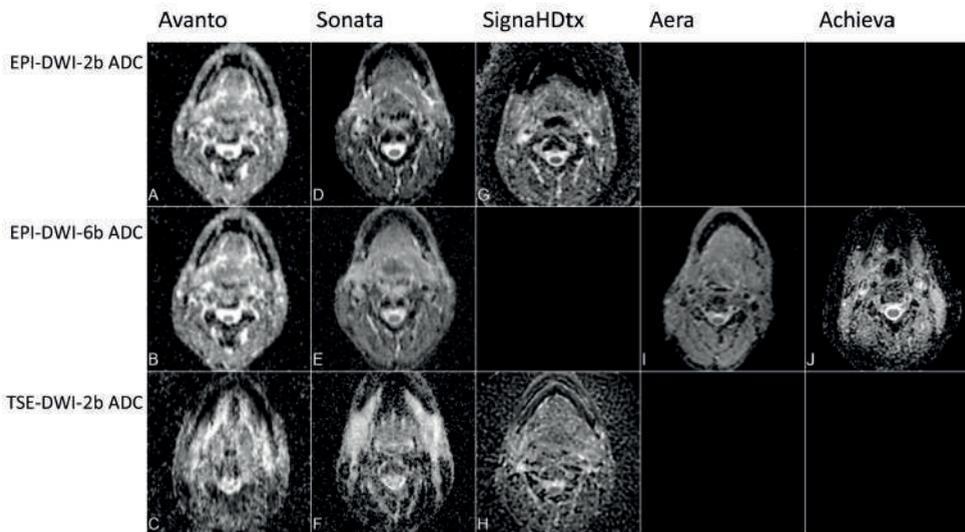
ADC maps of all DWI sequences on all MRI systems. On Signa HDtx EPI-DWI-6b was not performed. On Aera and Achieva EPI-DWI-2b ADC was extracted from EPI-DWI-6b and TSE-DWI-2b was not performed.
